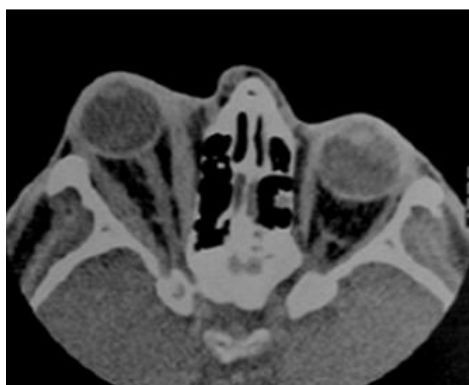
plain CT show thickening of medial and lateral rectus muscles of right orbit.
